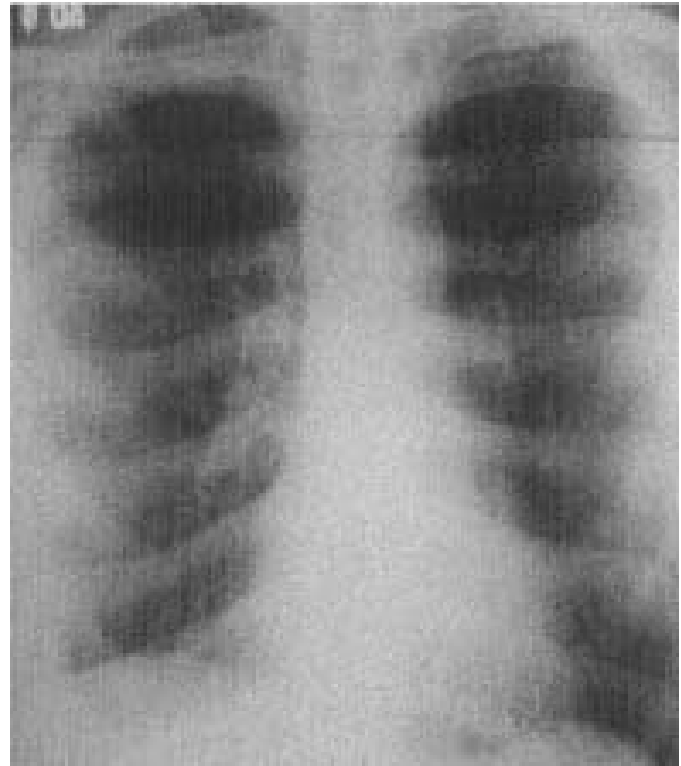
Chest radiograph PA view showing significant resolution of effusion after fibrinolytic therapy
